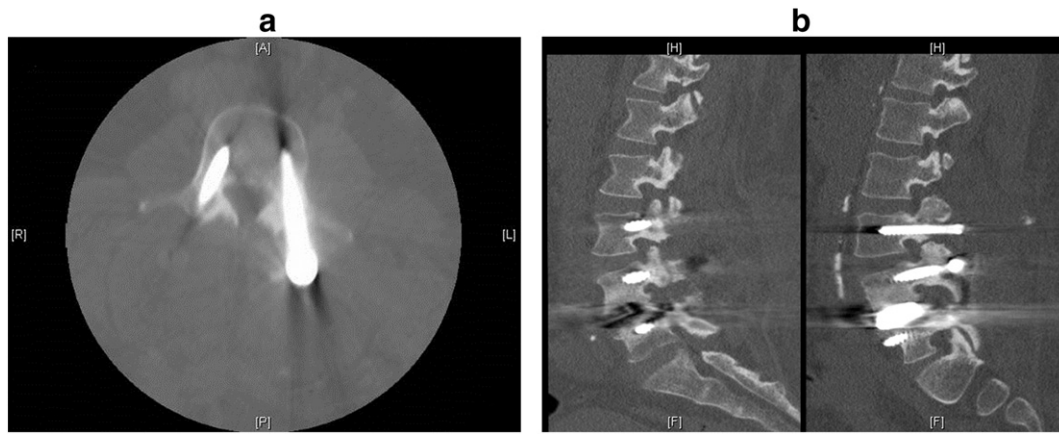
A) Axial and B) sagittal computed tomography (CT) scans obtained immediately postoperatively, demonstrating intact left L3 bone-screw interface.
